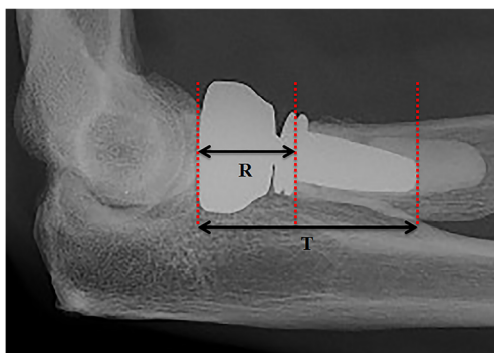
The CQ ratio, describing the head length (R) divided by total implant length (T) of a prosthesis (lateral radiograph of rHead® RECON prosthesis), and exceeding 0.4. The risk of instability is significantly higher secondary to increased micromotion of this short stemmed implant
